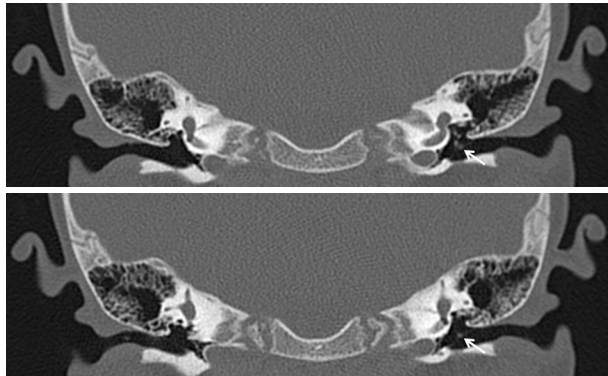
Coronal CT scans of the temporal bones showing a small soft tissue mass (arrows) located on the umbo of the left tympanic membrane. CT: computed tomography.
